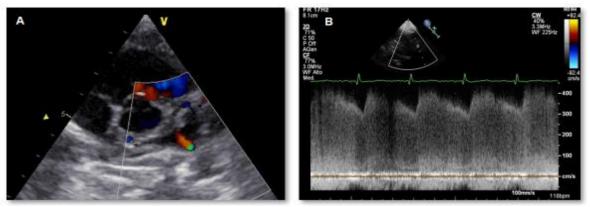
A: Transthoracic echocardiography in a short axis view showed a small patent ductus arteriosus (PDA) that measured 1.5 mm at its pulmonary end leaving left to right shunt. B: Continuous wave Doppler across the PDA showed a peak systolic pressure gradient of 76 mmHg and a diastolic one of 45 mmHg.
